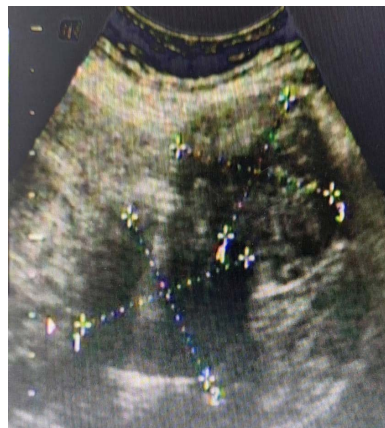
Ultrasound images of a polomyomatous and empty globular uterus.
